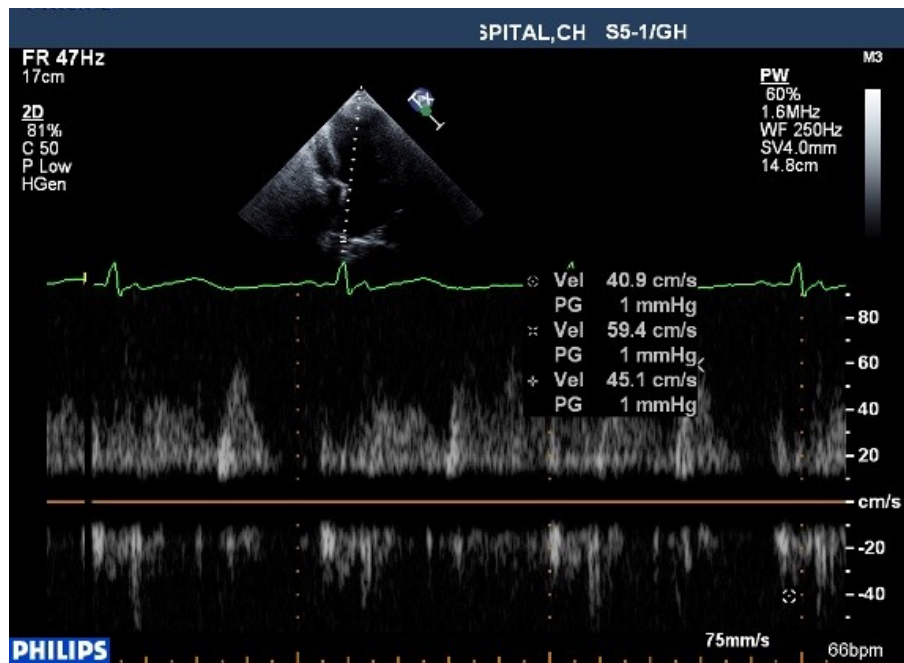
Pulmonary venous flow Doppler in a patient with AWTMI showing $S < D$. Atrial reversal velocity is increased
